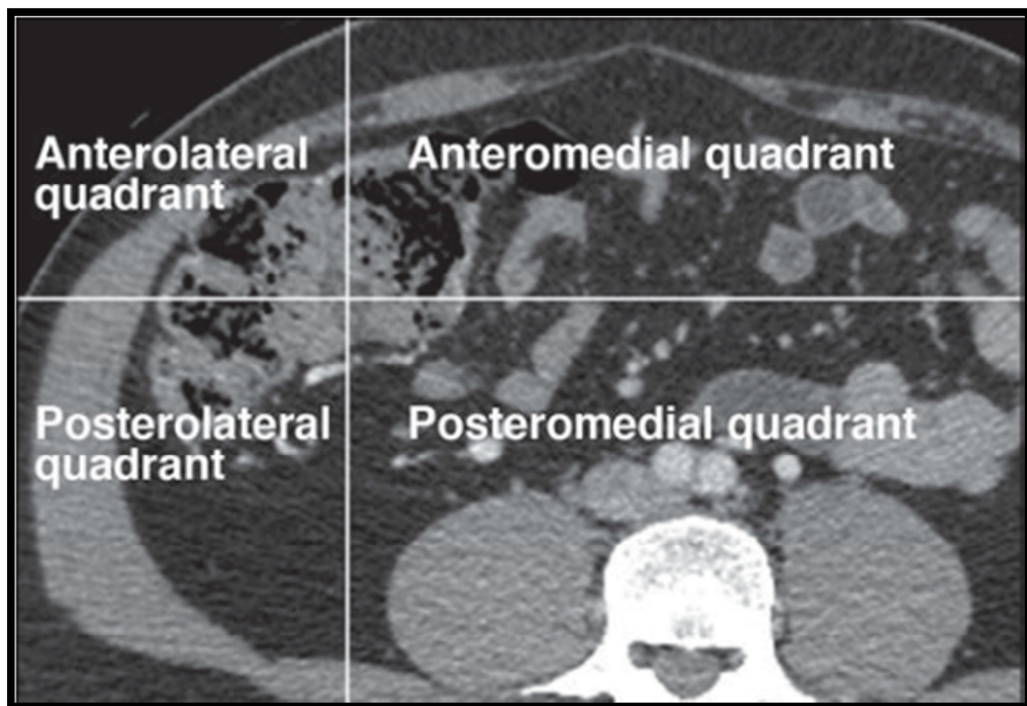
Axial view of appendix on CT
